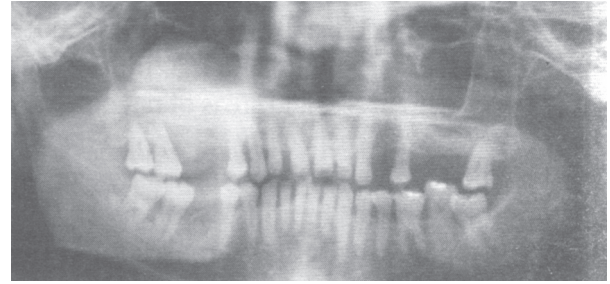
Orthopantomogram with dome shaped homogenous radioopacity over the corresponding right maxillary posterior region.
